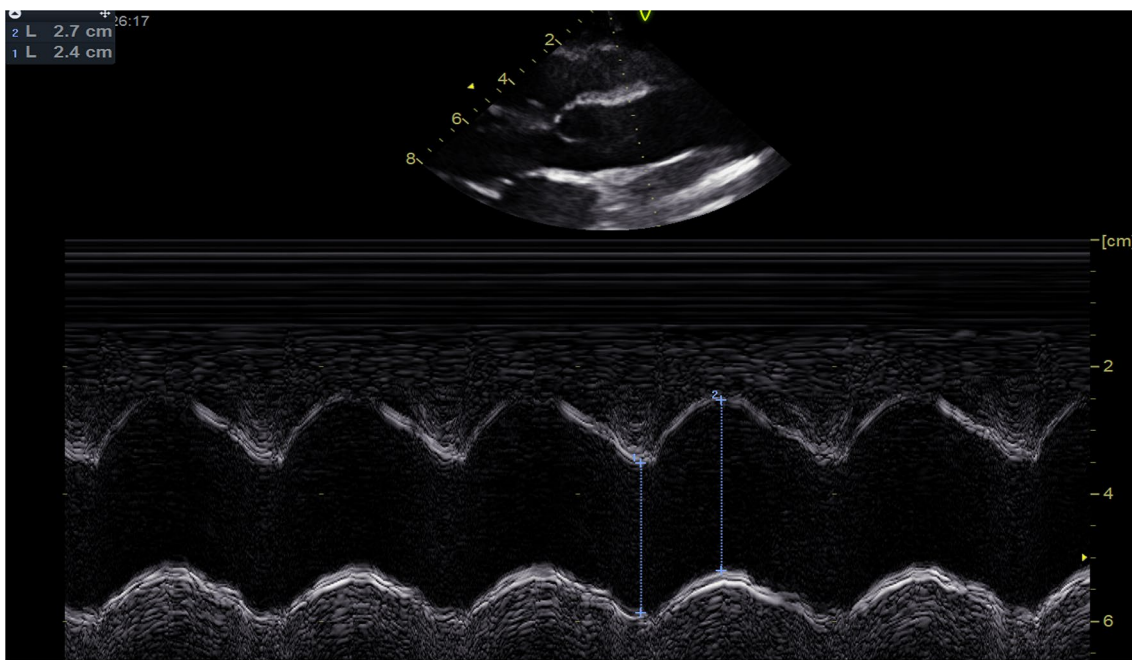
Aortic distensibility measurement using M-mode in the parasternal long axis view using transthoracic echocardiography. Measurement of aortic distensibility and stiffness using the internal aortic
